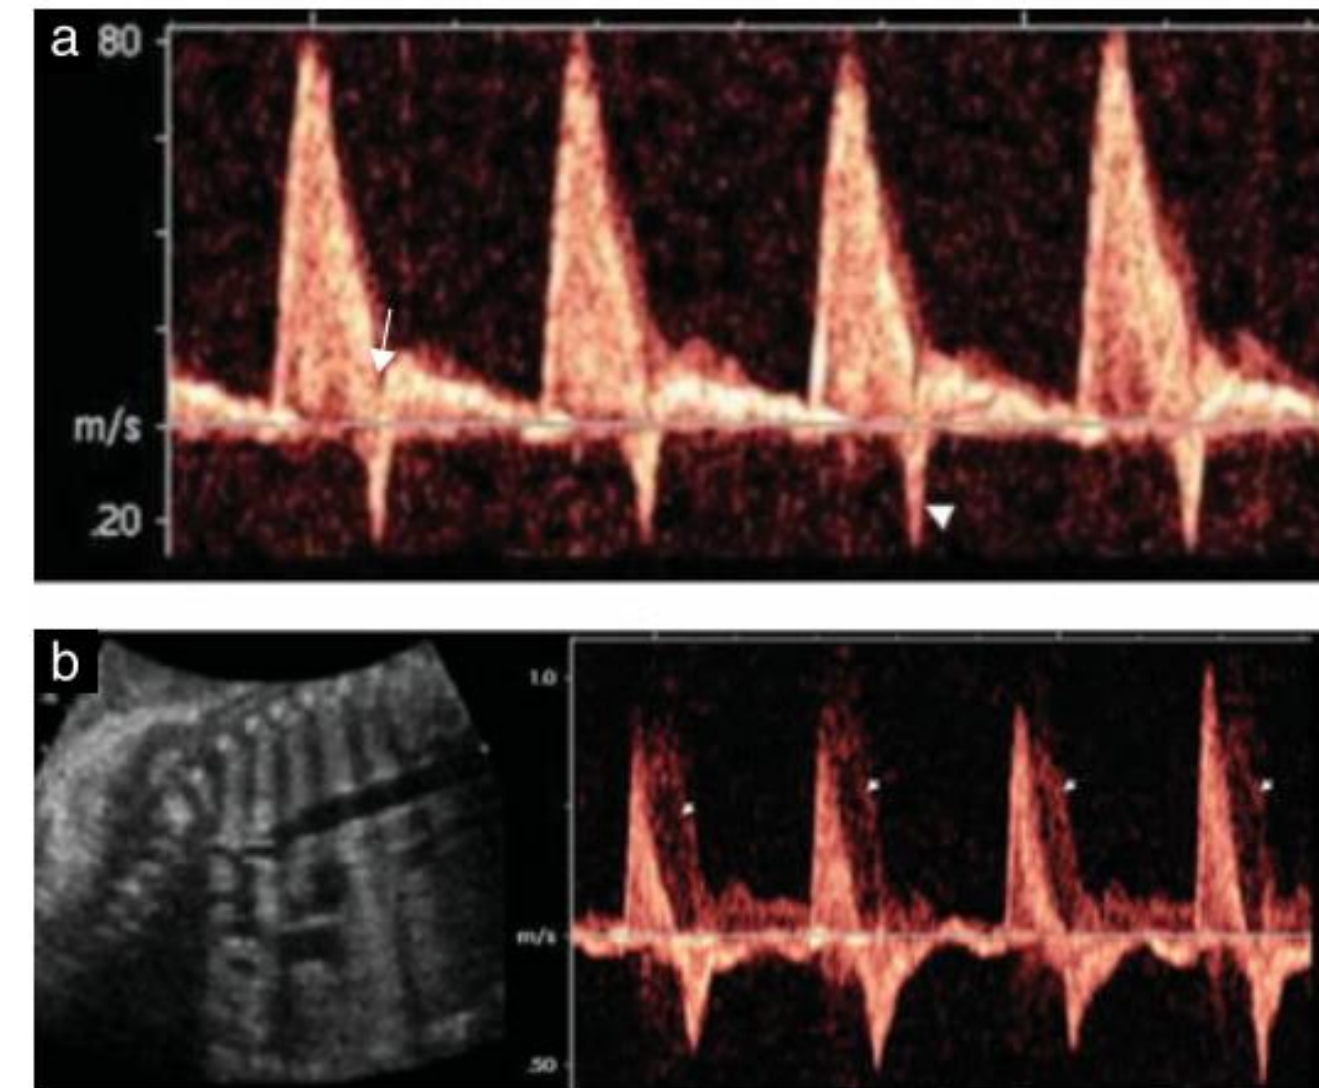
Typical normal (a) and abnormal (b) aortic isthmus Doppler flow velocity waveforms in the third trimester. In (a), the arrow points to the incisura and the arrowhead points to the brief retrograde flow at end-systole. In (b), small arrowheads point to the ductus arteriosus blood flow velocity waveforms in the background. Note that the aortic isthmus flow is reversed in late systole and the whole of diastole (net flow is retrograde).
